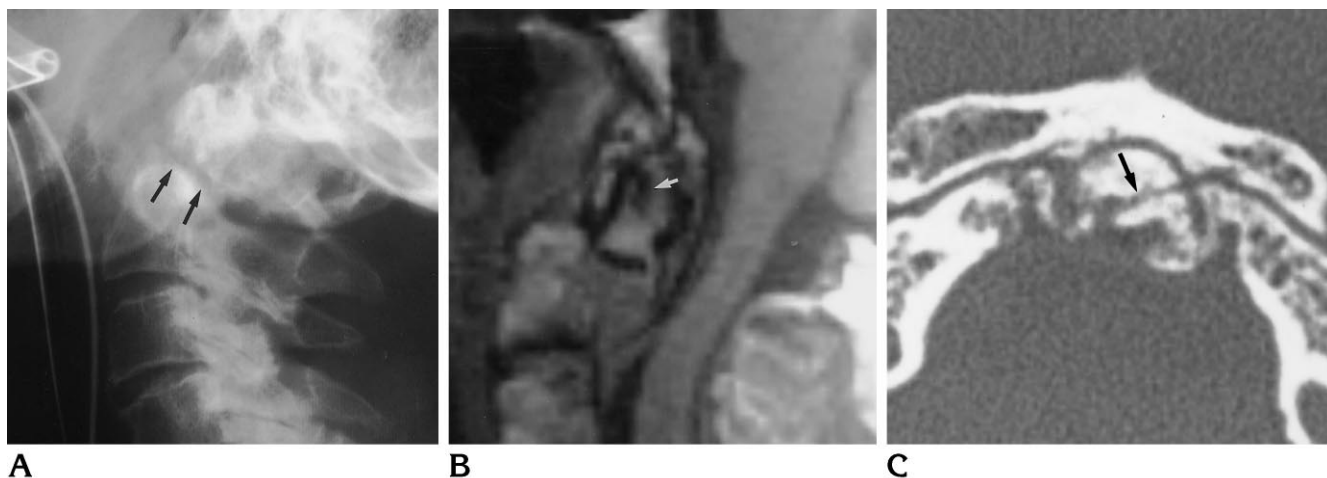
A, Lateral radiograph obtained with cross-table lateral technique shows type 2 fracture (arrows) at base of dens with posterior angulation. The vertical dens fracture is not appreciated on this study.
